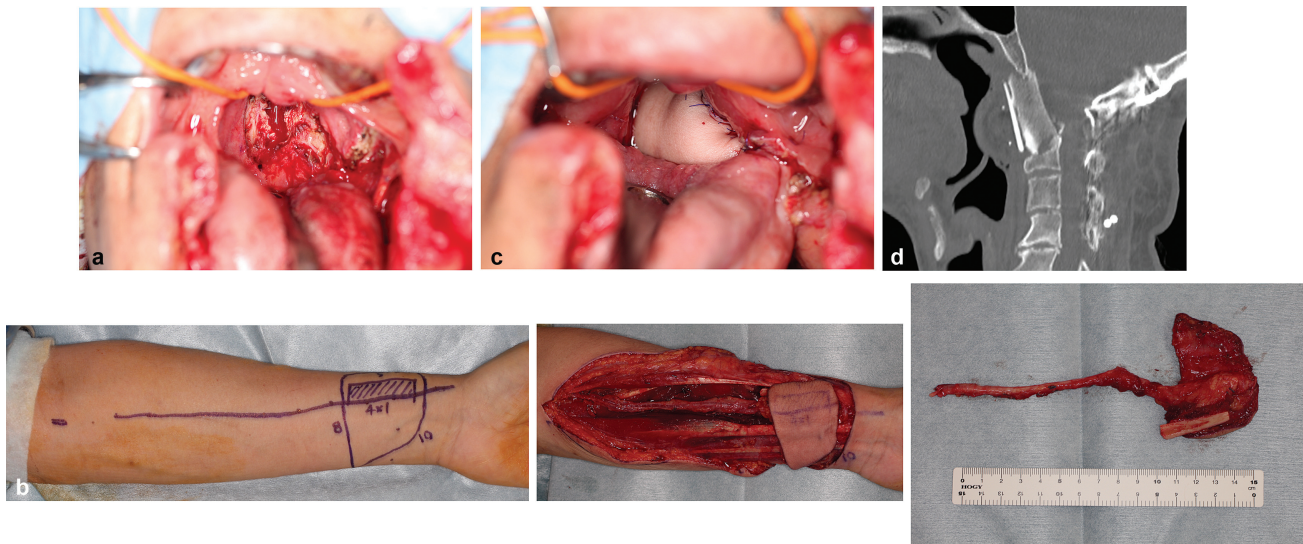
(a) Pharyngeal posterior wall following debridement. (b) Radial forearm flap. (c) Suture of the osteocutaneous flap. (d) Computed tomography (CT) scan at 1 month postoperatively.
